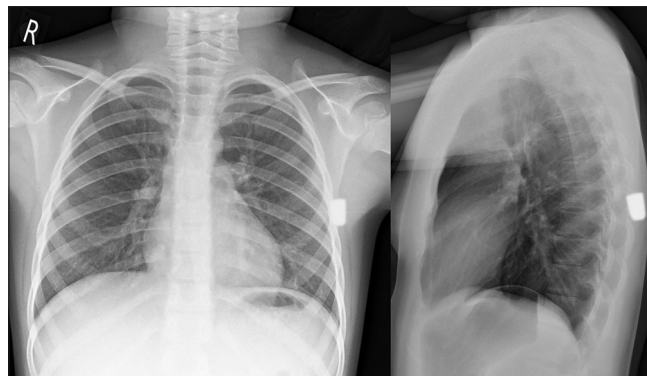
Chest radiography of the patient
